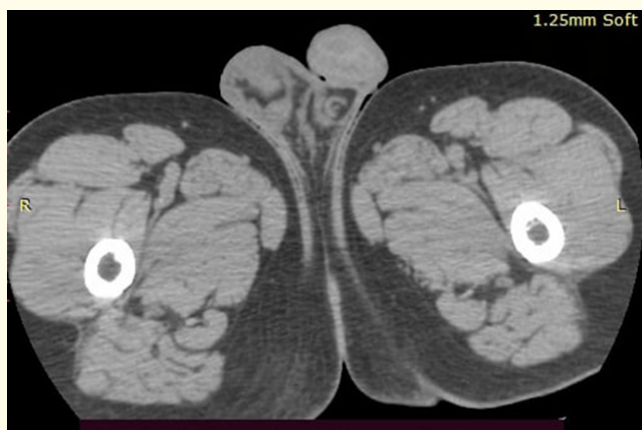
Axial CT scan showing right supra-spermatic cord nodular thickening with soft tissue strands and inflammatory changes.
